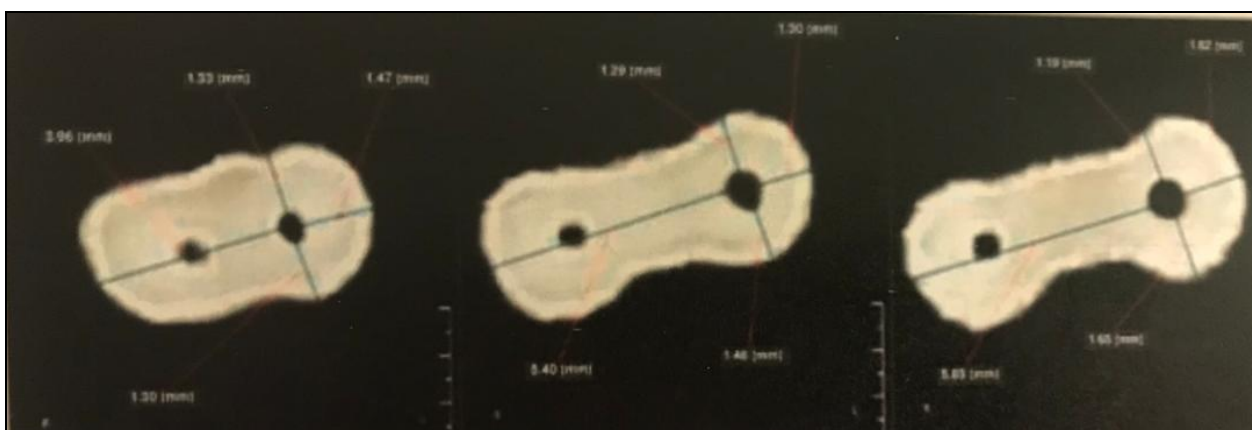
Post-instrumentation CBCT at three 3 mm, 6 mm, and 9 mm levels following preparation with Pro Taper Gold
